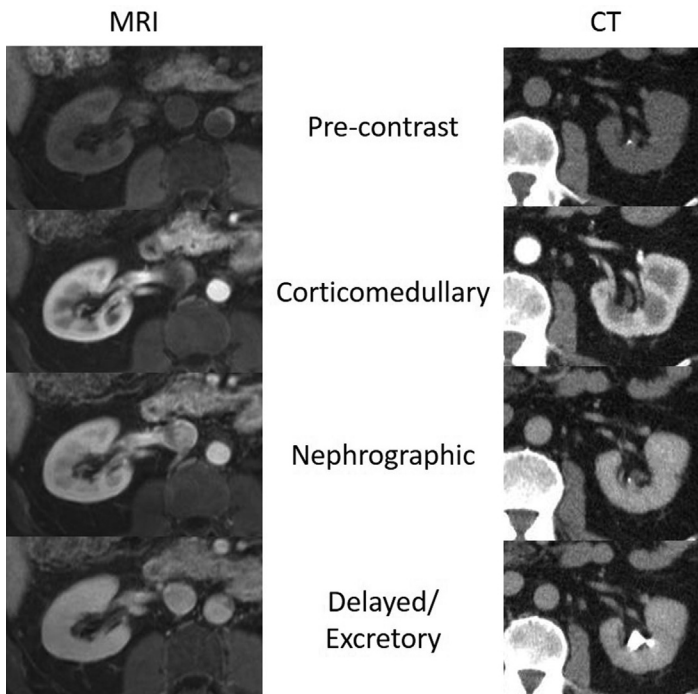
Precontrast, corticomedullary, nephrographic, and delayed/excretory phases on both CT and MRI.
